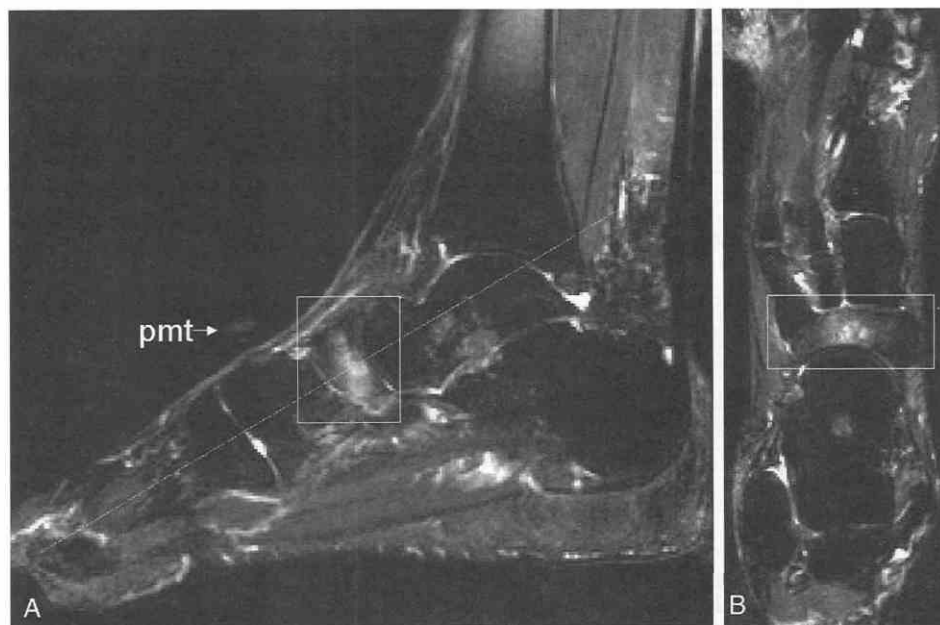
The patient (same as in Fig. 47-36) is a 45-year-old woman with pain over the dorsum of the midfoot. A, Sagittal fat-suppressed T2-weighted image. There is bone marrow edema within the navicular (*white rectangle*). This stress fracture of the navicular corresponds to the point of maximal tenderness (*pmt*), as indicated by the capsule on the skin. The *dashed line* indicates the location of the oblique axial slice in B. B, Oblique axial fat-suppressed T2-weighted image. This secondary plane helps confirm the bone marrow edema within the navicular (*white rectangle*).
